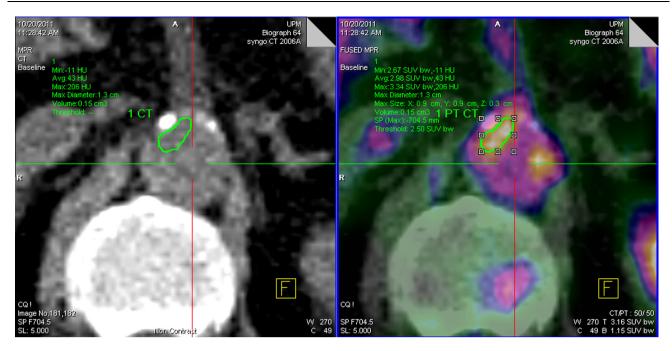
Inflamed vascular plaque at 10 o'clock position with CT value of 43 (mean HU) and metabolic activity of SUVmax: 3.34.
